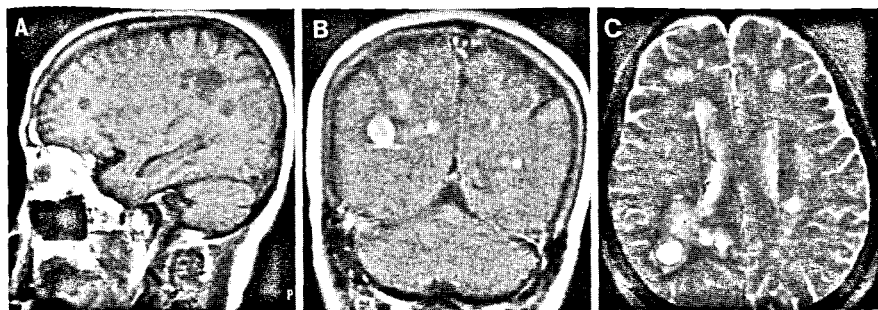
MRI scan (T1-weighted with gadolinium enhancement) shows multiple contrast-enhancing frontal, parietal, occipital, and periventricular white matter lesions (B) hypointense to gray matter on T1-weighted images (A) and hyperintense to gray matter on T2-weighted images (C).
